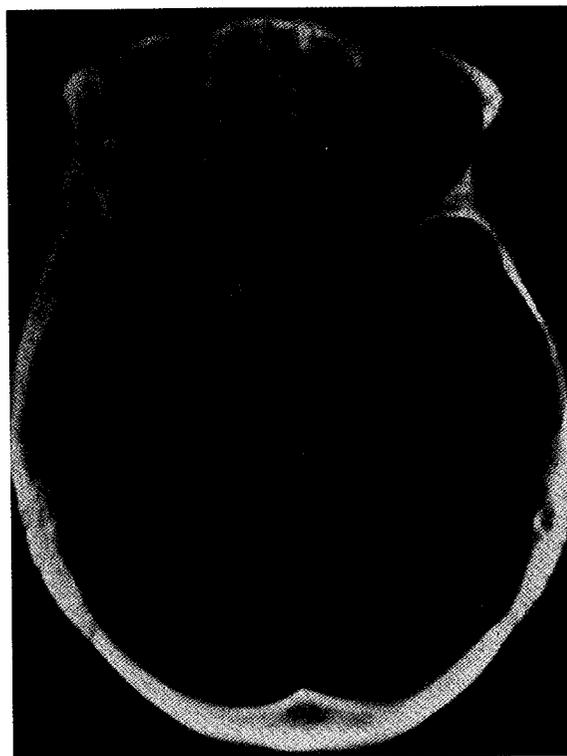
CT of the skull shows right unilateral bone thickening of the orbit and ethmoidal cells.
